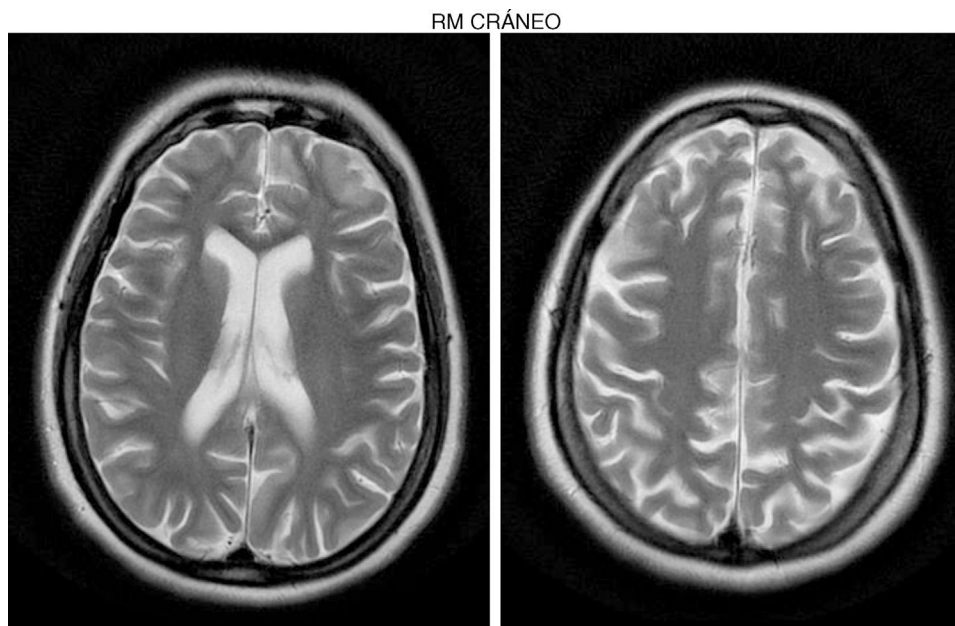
Patient 1. Axial T2-weighted TSE sequence showing cortical retraction with slight dilation of the subarachnoid spaces of the convexity, and discrete enlargement of the supratentorial ventricular system.
